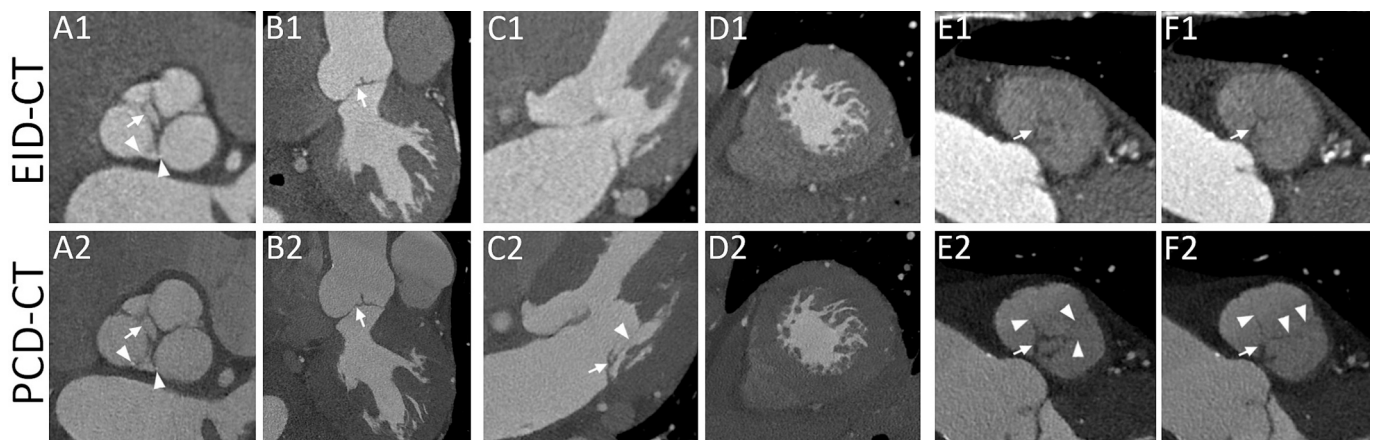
Examples of aortic (A and B), mitral (C and D) and pulmonary (E and F) valves of the same patient with EID-CT (first line) and PCD-CT (second line). A and B: multiplanar reconstructions perpendicular (As) and parallel (Bs) to the aortic root show an irregular profile of the non-coronary cusp (arrows). The cusps, the commissures and this irregular zone of the aortic valve are sharper with PCD-CT. In addition, some tiny calcifications (A1 and A2, arrowheads) are well visible with PCD-CT but hardly so with EID-CT. C and D: four-chambers (Cs) and short axis (Ds) plane reconstructions of the mitral valve and of the left ventricle trabeculations allow to appreciate the better conspicuity and sharpness of these structures with PCD-CT. In particular, with PCD-CT one entire chordae (C2, arrowheads) and its insertion on the posterior leaflet of the mitral valve were clearly visible, whereas with EID-CT only the position of the insertion point can be guessed when knowing it is there. E and F: multiplanar reconstructions passing on planes perpendicular to the pulmonary trunk at different levels of the pulmonary valve. With both EID-CT and PCD-CT the edges of the cusps appear thickened but with PCD-CT they are more clearly visible and sharper. In addition, only with PCD-CT the commissures are visible (arrowheads).
